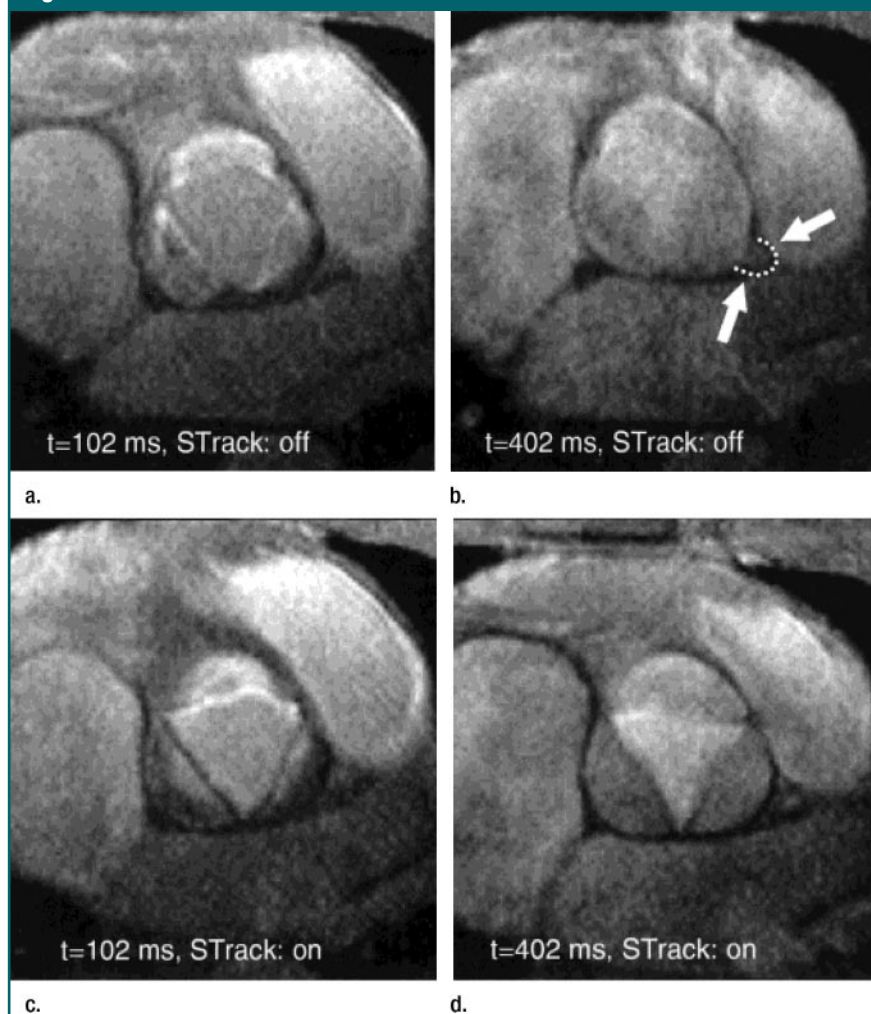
(a–d) Magnitude MR images of cross section of aortic valve at two time points (t) in the cardiac cycle, with and without section tracking (STrack). Section tracking enables valve to be seen with greater clarity at both time points. Arrows in b highlight left coronary root, which has moved into the imaging frame since a but is rightly absent in d. (Reprinted, with permission, from reference 85.)
